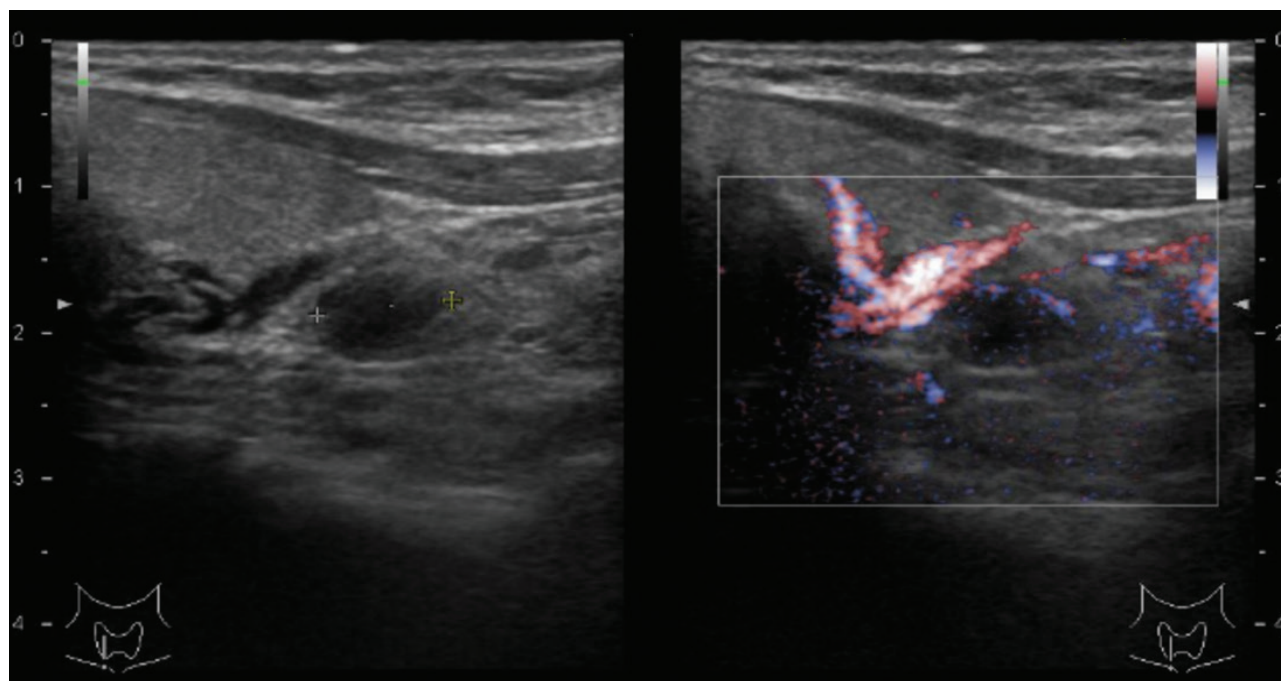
A parathyroid adenoma was identified adjacent to the lower pole of the right thyroid lobe. The left image shows a solid lesion with 8.9 mm, rounded and well-circumscribed, hypoechoic with respect to the thyroid tissue. On the right image with Doppler technique a feeding artery is identified that enters the adenoma through one of its poles and is distributed towards the periphery (vascular arch pattern).
